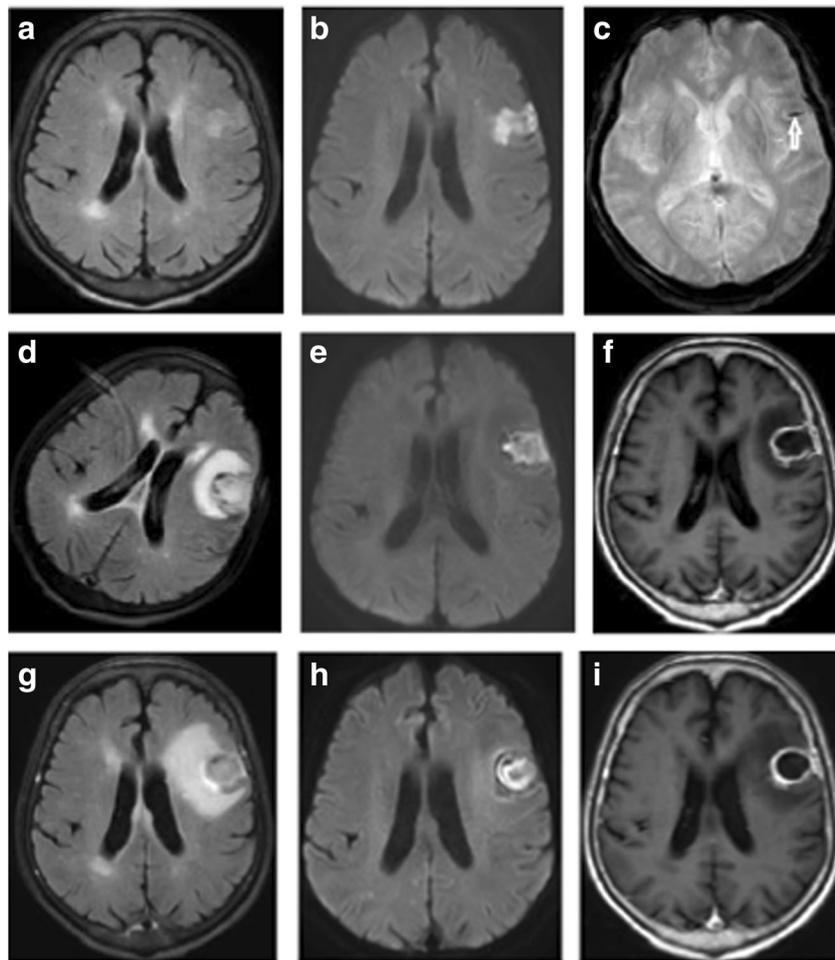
Patient 2. a–c MRI performed 2 days later after onset of slurred speech. a FLAIR shows irregular patchy hyperintensity in the left frontal lobe which is hyperintense on DWI (b). ADC image shows that diffusion is restricted. All these are consistent with acute infarction. c T2*WI shows hemorrhagic transformation in the lesion of the left frontal lobe (arrow). The patient's condition was improved after treatment with antibiotic, antiplatelet, lipid-modulating, and anticoagulant therapy. On the 15th day, his slurred speech worsened and delirium occurred. *Staphylococcus aureus* was identified in the blood cultures. d–f MRI
